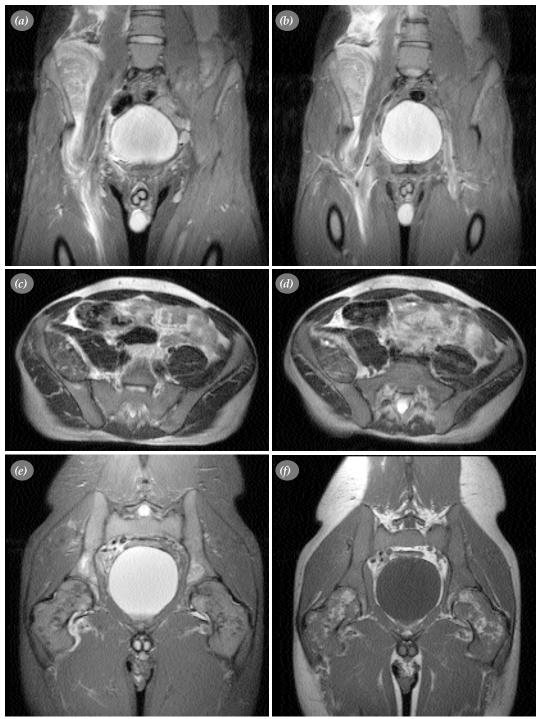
(a, b) An intrapelvic tumoral lesion, measuring 20x8x5 cm and extending the hip joint, was detected adjacent to the right iliopsoas and iliac bone on T₂ weighted coronal MR images.
